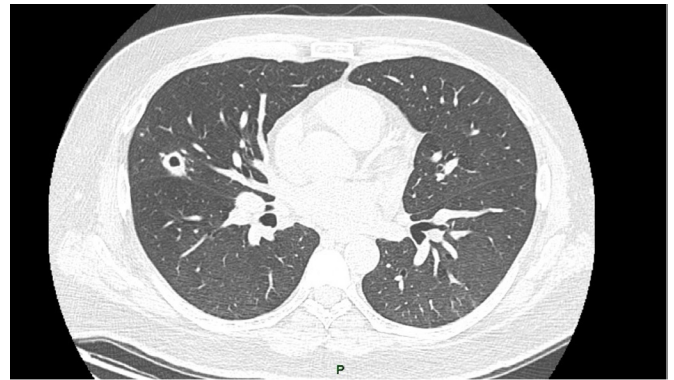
Chest CT scan on day 14 after discharge.
